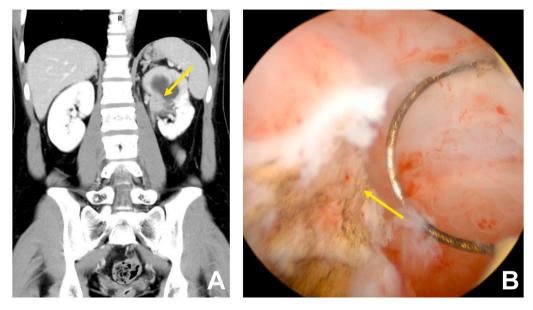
Interval CT scan; the venous phase showed a significant growth of the mass in the left renal pelvis (2A). Percutaneous endoscopic view demonstrated a cautery loop resection of the renal pelvic mass (2B).
